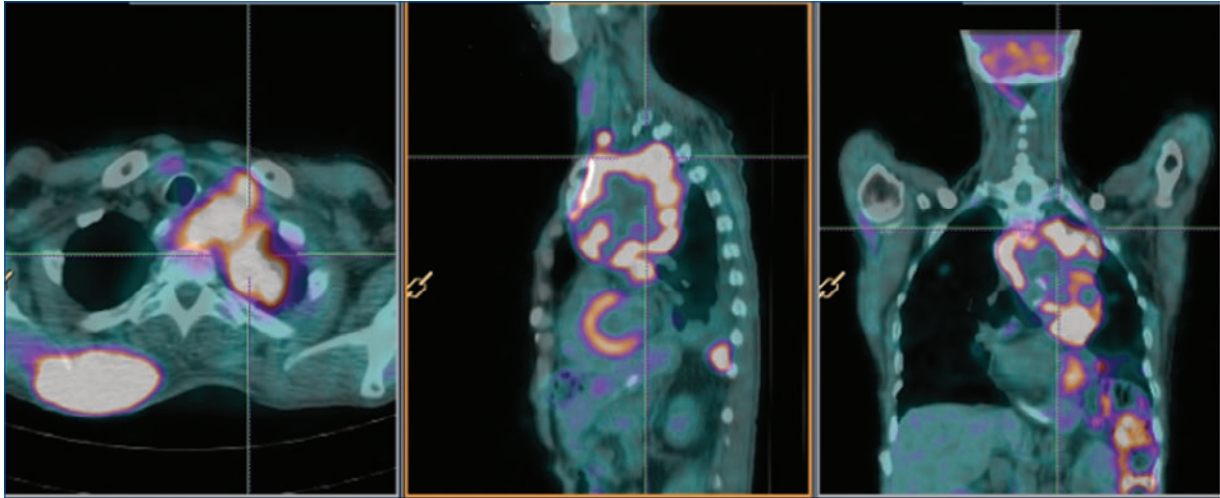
Head CT scan and positron emission tomography demonstrated metastatic lesions in the central nervous system, colon, muscle and bone.
